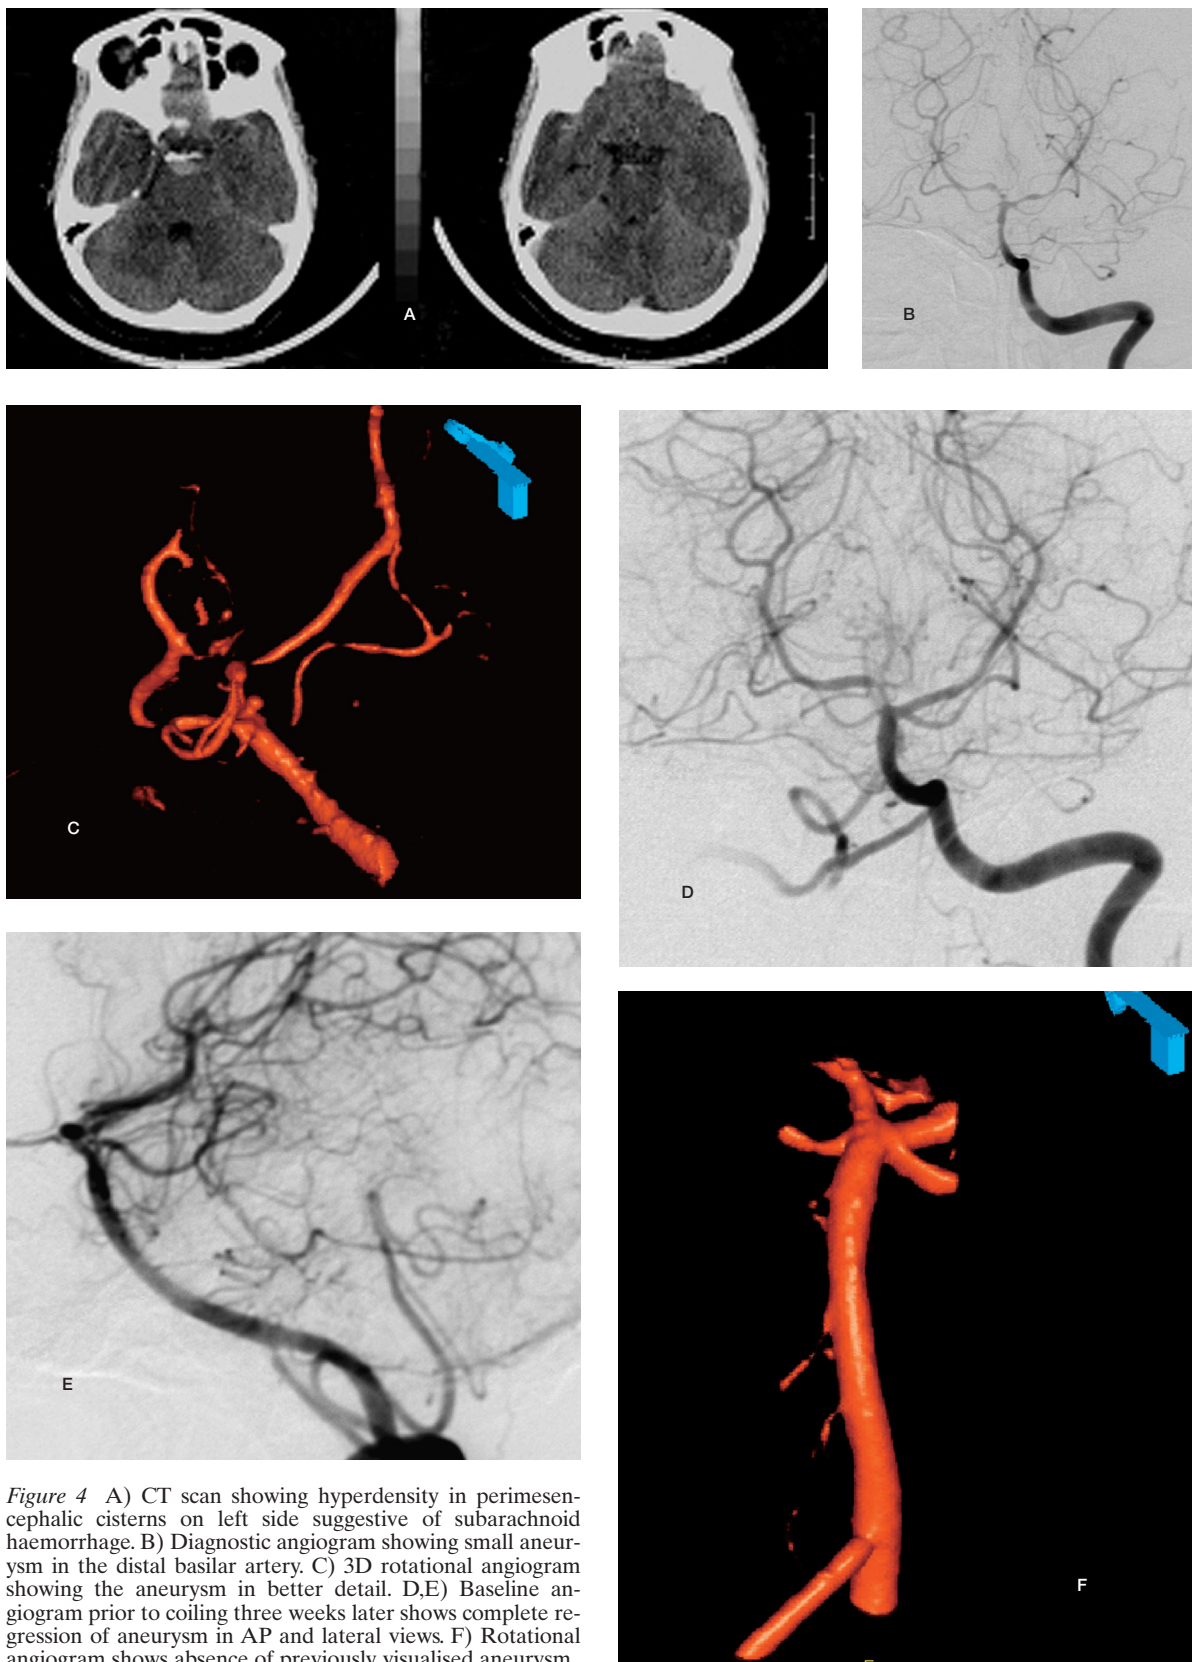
A) CT scan showing hyperdensity in perimesencephalic cisterns on left side suggestive of subarachnoid haemorrhage. B) Diagnostic angiogram showing small aneurysm in the distal basilar artery. C) 3D rotational angiogram showing the aneurysm in better detail. D,E) Baseline angiogram prior to coiling three weeks later shows complete regression of aneurysm in AP and lateral views. F) Rotational angiogram shows absence of previously visualised aneurysm.
